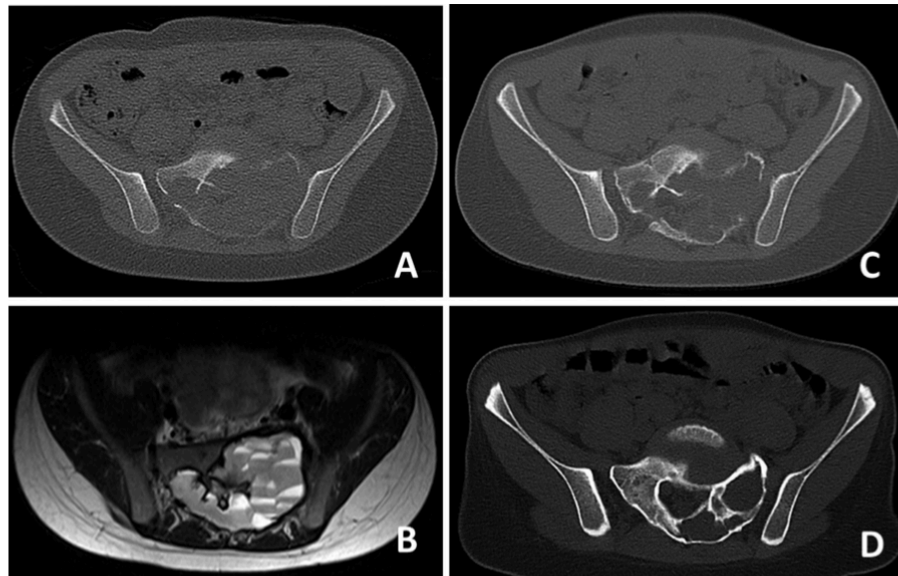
CT-scan (A) showing massive osteolytic destruction of the sacrum at the levels S1 and S2 caused by ABC. (B) The lesions shows typical fluid- fluid levels on T2-weighted TSE imaging with the patient in supine position, which is a sign of internal bleeding within the cysts. (C) CT-scan two months after initiation of treatment with Denosumab showing initial sclerotic demarcation of the lesion and increased sclerosis. (D) CT-scan after one year of treatment demonstrating stable osseous reconstitution of both sacral ala.
